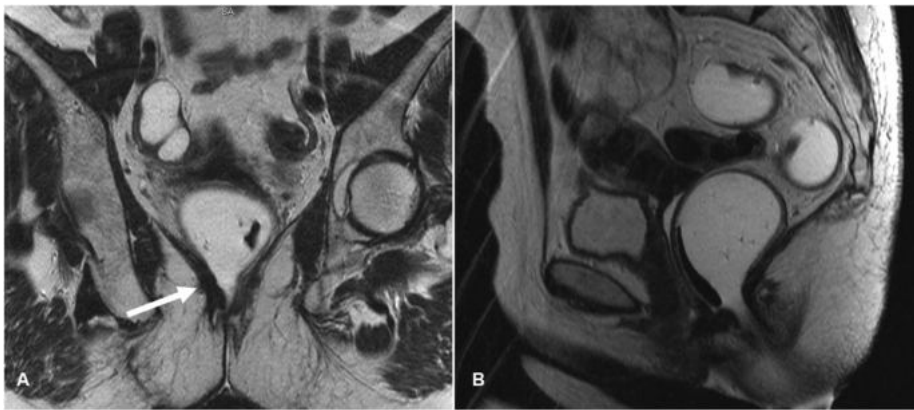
Fecal incontinence. Coronal (A) and Sagittal (B) MRI T2WI shows bilateral atrophy of the levator ani, with fibrosis on the right (white arrow) in a patient with fecal incontinence for solids.
